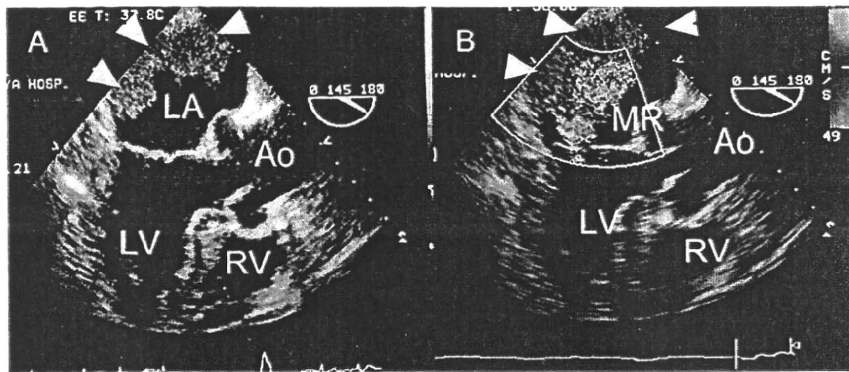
Trans-esophageal echocardiograms showing a giant thrombus (arrow heads) in the left atrium at the first admission. (A) Moderate mitral regurgitant jet blowing and encroaching on the surface of the thrombus. (B) LV indicates left ventricle; RV, right ventricle; LA, left atrium; Ao, aorta.
